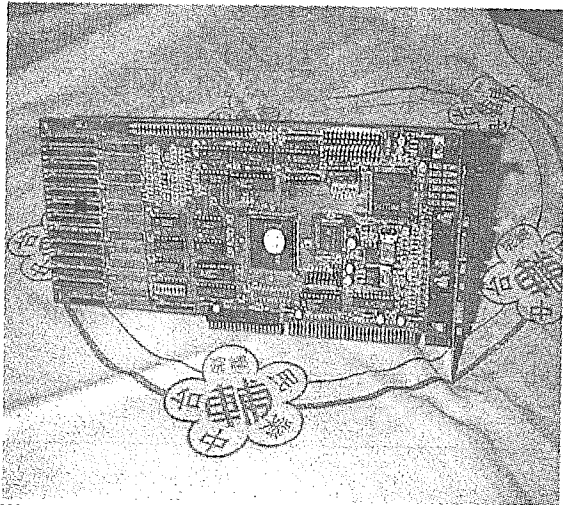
A PDI Tecon image grabbing board used to digitize the ultrasound images.
